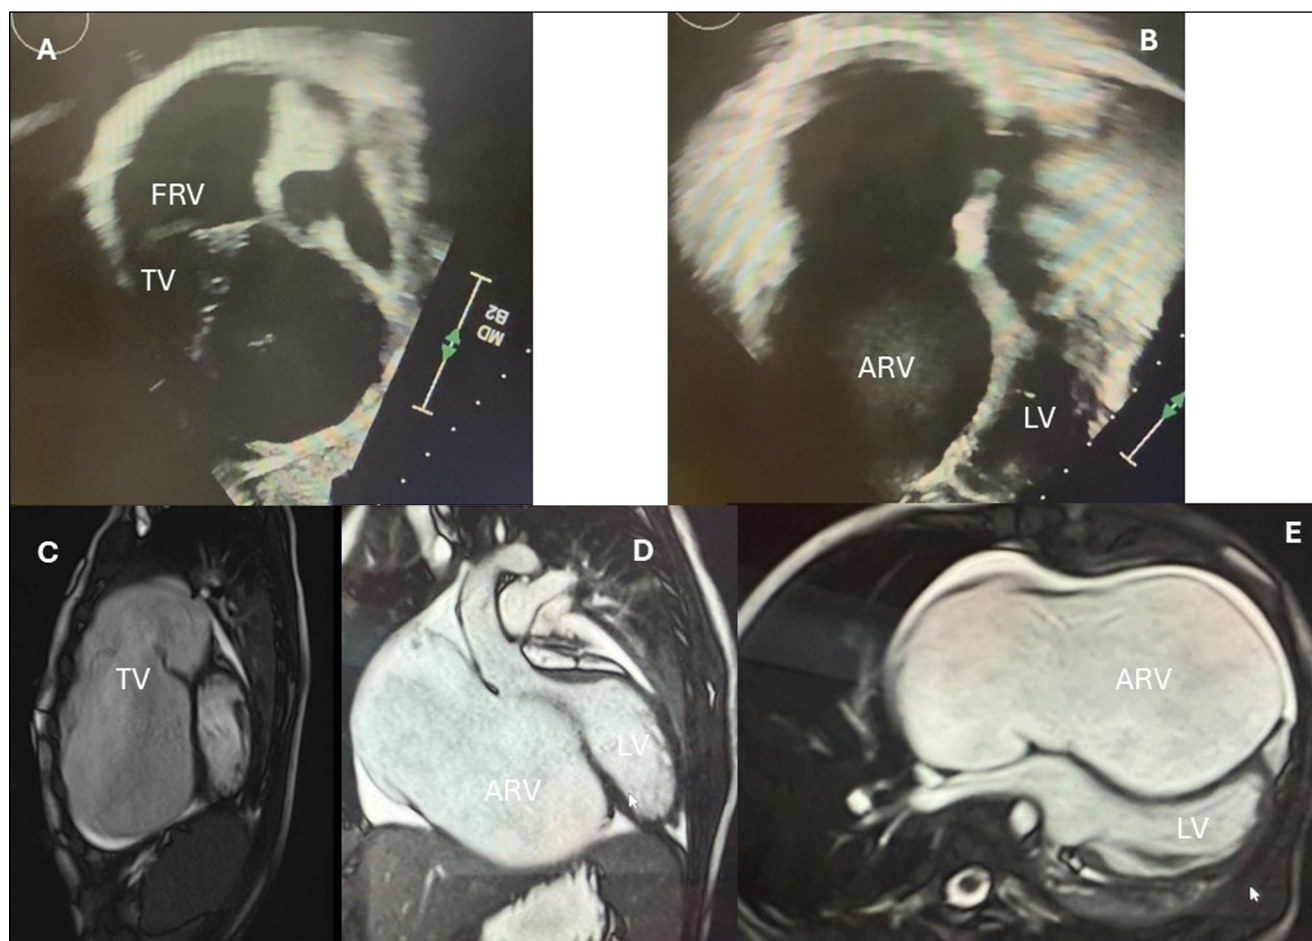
Severely rotated tricuspid valve. (A) Echocardiogram subcostal view exposing the tricuspid leaflets in the right ventricular outflow tract (RVOT), with a very small functional right ventricular (RV) chamber. (B) Echo 4-chamber view showing a large atrialized RV and no tissue in the septal area. The septal leaflet compresses the LV cavity. (C) Magnetic resonance imaging shows images showing the rotated TV in the RVOT, and (D, E) the interventricular septum compressing the left ventricular cavity. FRV: functional right ventricle; TV: tricuspid valve; ARV: atrialized right ventricle; LV: left ventricle
